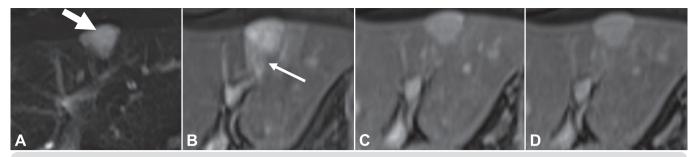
Type I hemangioma on dynamic MRI. A) T2-weighted image showing a well-defined hyperintense nodule (arrow). B) Arterial phase with intense enhancement and peripheric perfusion abnormality (arrow). C and D) Hyperintensity remains on portal-venous (C) and delayed (D) images, similar to the vessels.
